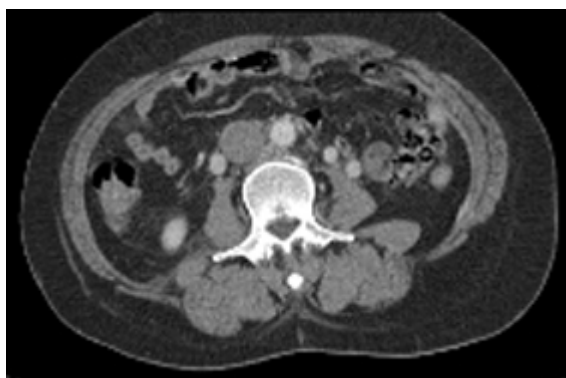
Abdominal CT scan shows filling of thrombi within the Trepease IVC filter and IVC.
